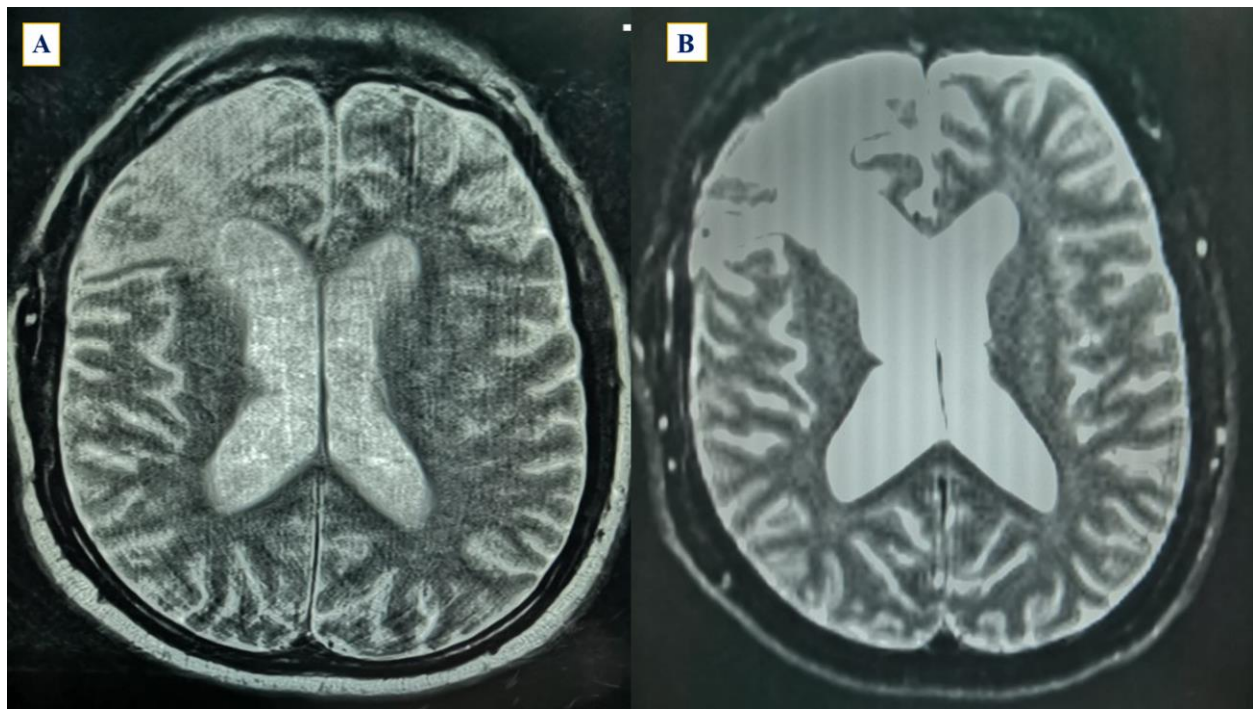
A and B Axial MRI of male 59-Year-old post trauma with Left parietal small EDH (epidural hematoma).
